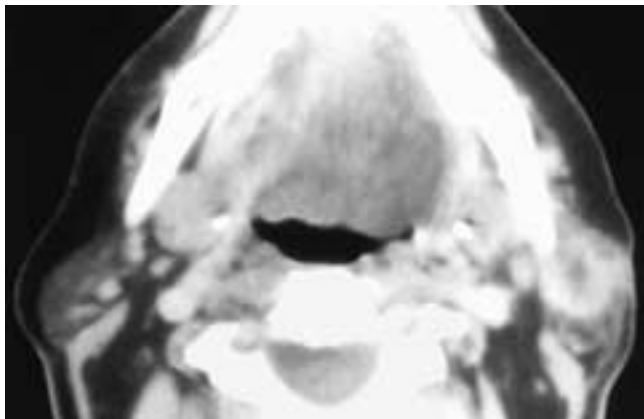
Axial contrast-enhanced CT scan shows a partially necrotic infiltrating mass in the left parotid gland in continuity with localized disease in the overlying skin. This patient had an SCC of the skin with extension to the parotid gland.
